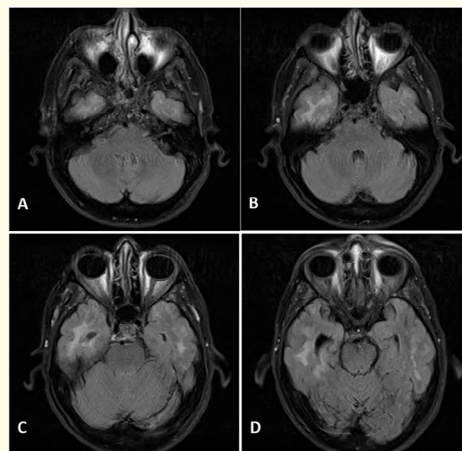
A-D showing different cuts of MRI showing bilateral temporal hyperintensities on T2 Flair.
